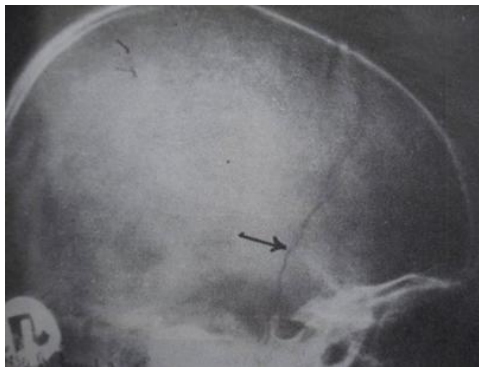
Lateral skull X-ray linear fracture
